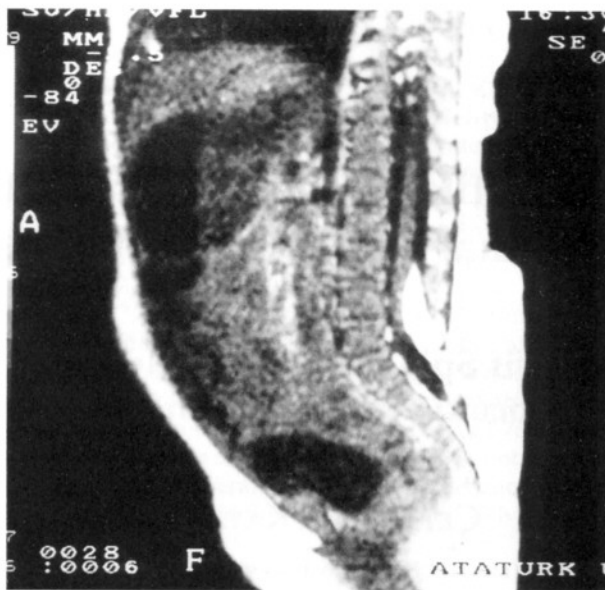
A midsagittal T1-weighted MR image of a dorsally inserting lipoma.
